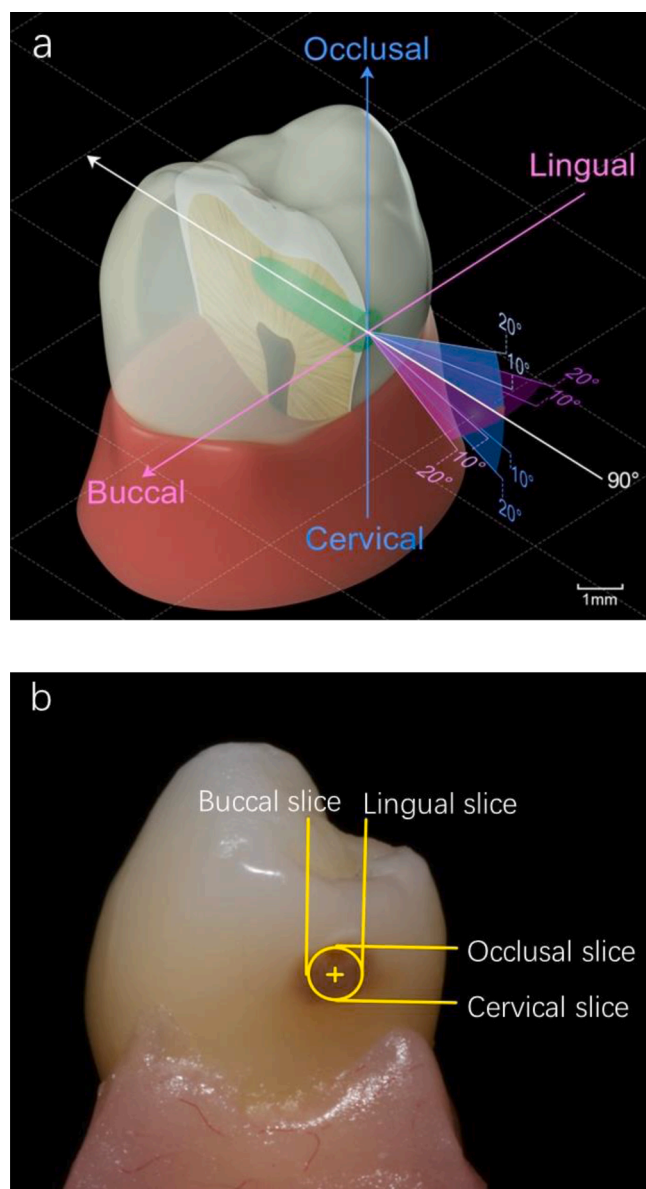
Different scanning angles and locations of analysis. Fig. 1a: 3D model showing different scanning angles. Pink color indicates buccal-lingual direction; blue color indicates occlusal-cervical direction. Hemispherical green area shows laser beam penetrating into tissue. Fig. 1b: Locations of analyzing slices on μ -CT images. Circle indicates location of scanning area and “+” shows center of laser beam and also center of analyzing slices on μ -CT images.
